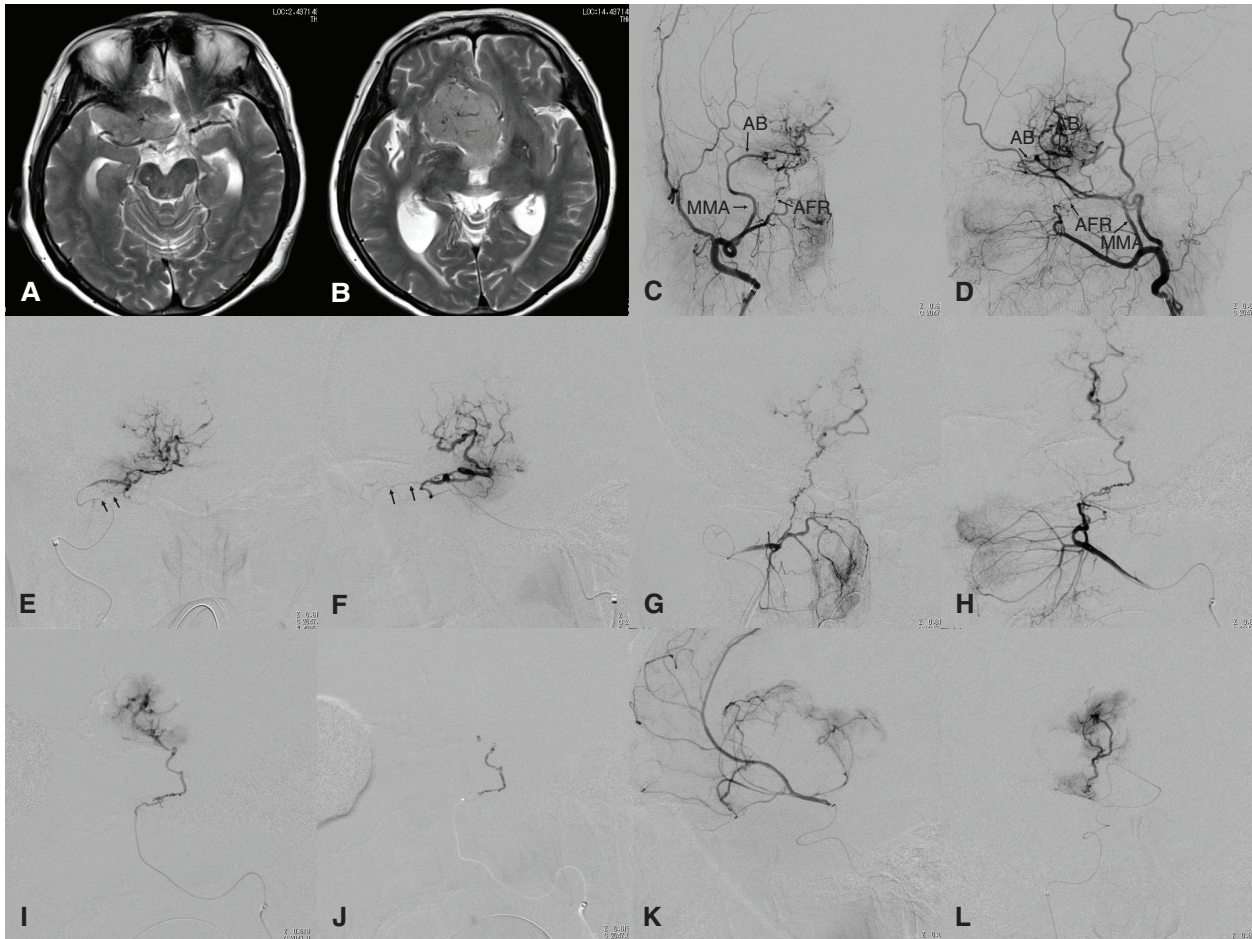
A large sphenoid ridge meningioma with pial arterial supply. (A and B) T2-weighted MR images show a large mass at the right sphenoid ridge growing upward and displacing the right frontal lobe. Frontal (C) and lateral (D) views on right external carotid angiography show strong contrast blush and markedly hypertrophied feeders from the AntB of the MMA and the AFR. Frontal (E) and lateral (F) views on selective angiography of the anterior branch of the MMA show marked dilated tumor vessels. An orbital branch (meningolachrymal artery, arrows) is noted. The anterior branch was embolized using large particles (300–500 Embosphere) and gelatin sponge pieces. Frontal (G) and lateral (H) views on selective maxillary
